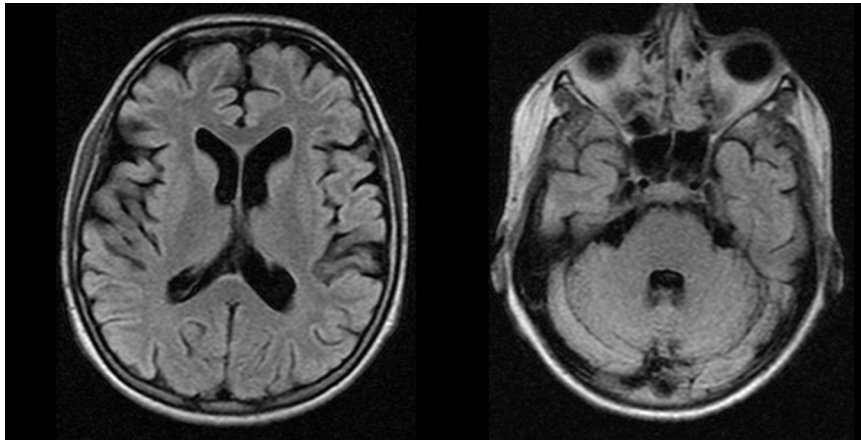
T2-weighted MRI of the brain.
